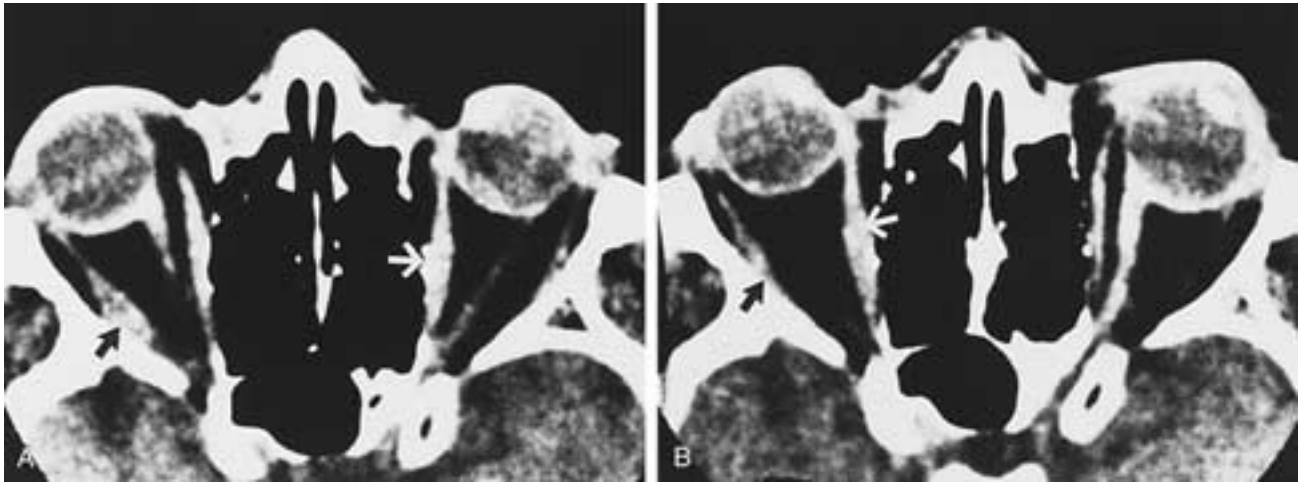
Demonstration of Sherrington's law of reciprocal innervation. A, Axial CT scan obtained during right lateral gaze. Note that the right lateral rectus muscle (*black arrow*) and the left medial rectus muscle (*white arrow*) contract, and the right medial and left lateral rectus muscles relax (lengthen). B, Axial CT scan obtained during left lateral gaze. Right medial rectus muscle (*white arrow*) and left lateral rectus muscle are contracted, and right lateral rectus muscle (*black arrow*) and left medial rectus muscle are relaxed (lengthened). (From Mafee MF et al. CT in the evaluation of Brown's superior oblique tendon sheath syndrome. Radiology 1985;154:691–695.)
